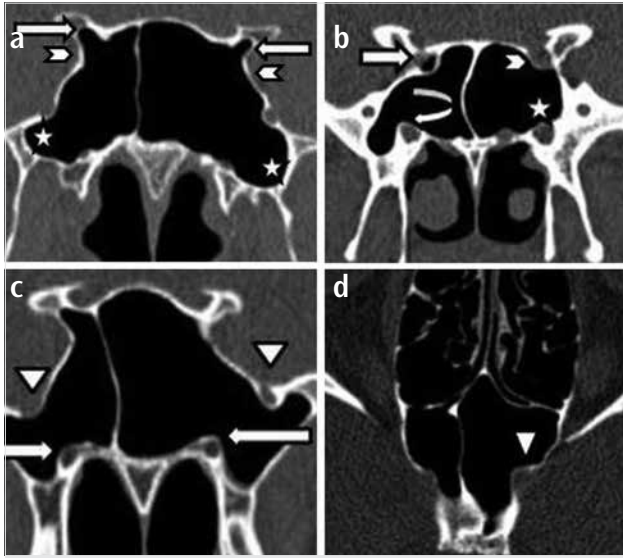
a-d. Coronal CT images of different patients showing: pneumatization of bilateral anterior clinoid processes (arrows) and bilateral pterygoid processes (asterisks) and protrusion of the bilateral internal carotid arteries (arrowheads) (a), protrusion of the right optic nerve (arrow), dehiscence of the left optic nerve (arrowhead), protrusion of the right vidian nerve (curved arrow), dehiscence of the left vidian nerve (asterisk) (b), protrusion of bilateral vidian nerves (arrows), dehiscence of the right maxillary nerve and protrusion of the left maxillary nerve (arrowheads), (c) axial CT image of a different patient showing dehiscence of the left internal carotid artery (arrowhead) (d)
